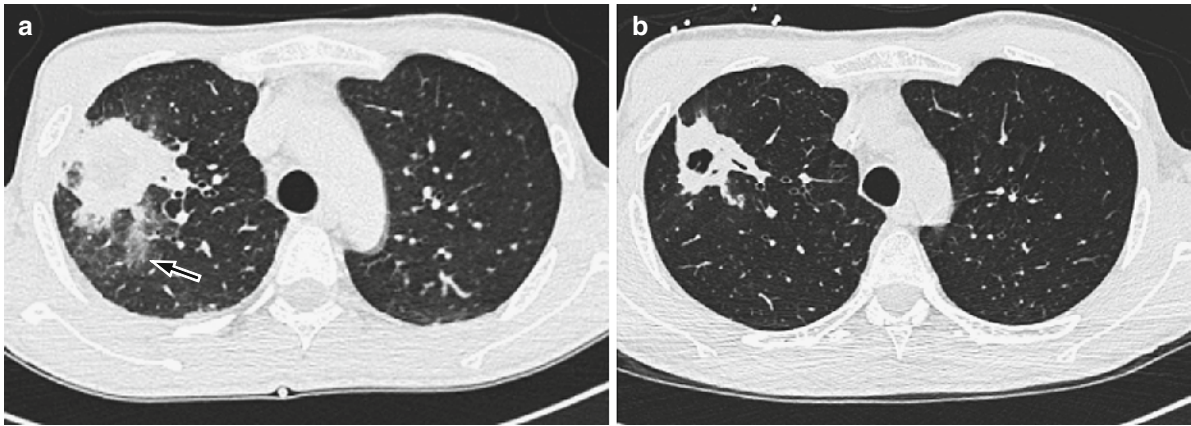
CT scan appearance of invasive pulmonary aspergillosis in a 35-year-old patient undergoing chemotherapy for acute myeloid leukemia secondary to myelodysplasia. (a) Peripheral
